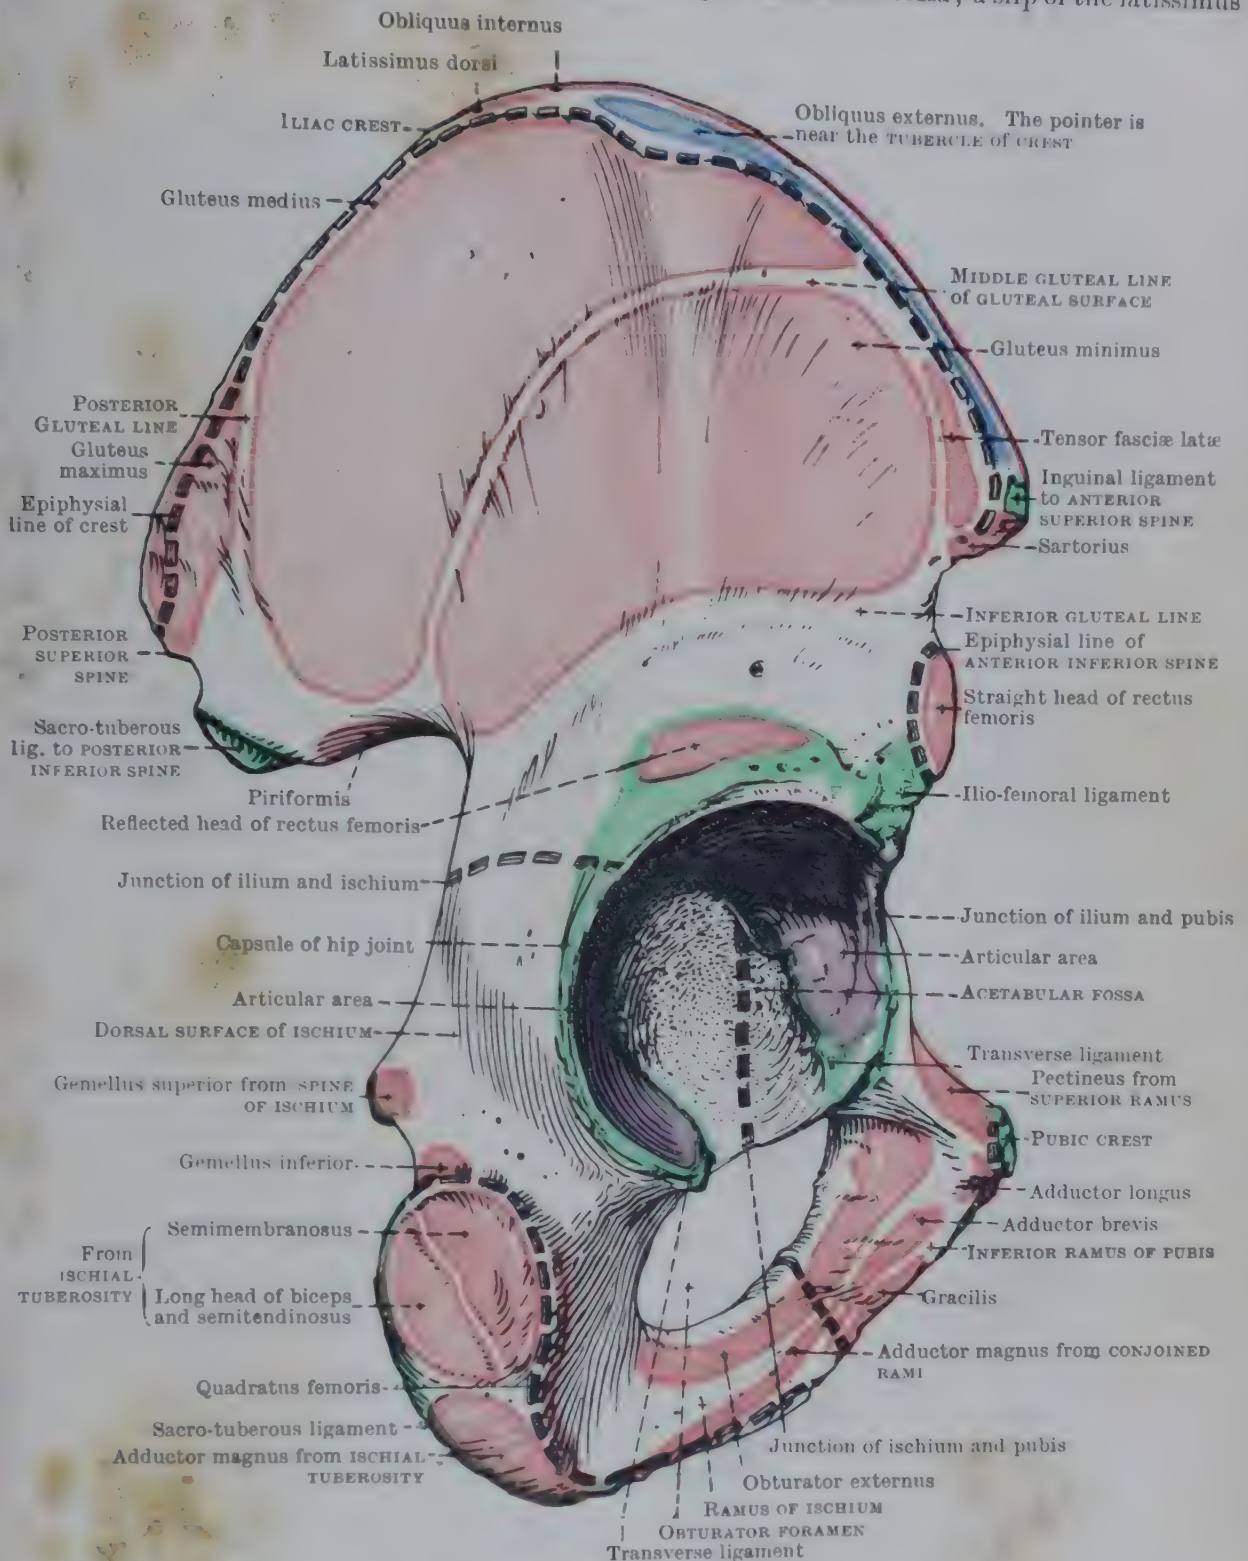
LATERAL ASPECT OF RIGHT HIP-BONE.
